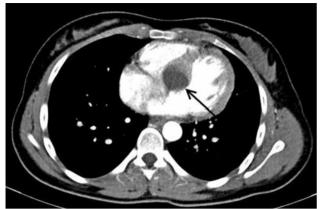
Thoracic computed tomography of the cyst in the interventricular septum (arrow).
